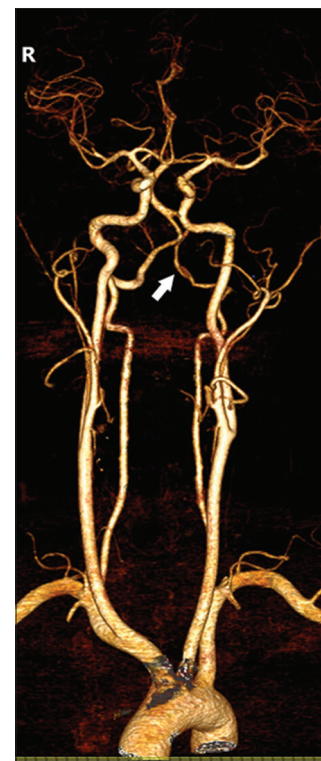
Reconstructed computed tomography with angiography (CTA) revealed dissection of the third and fourth segment of the left vertebral artery (white arrow)
